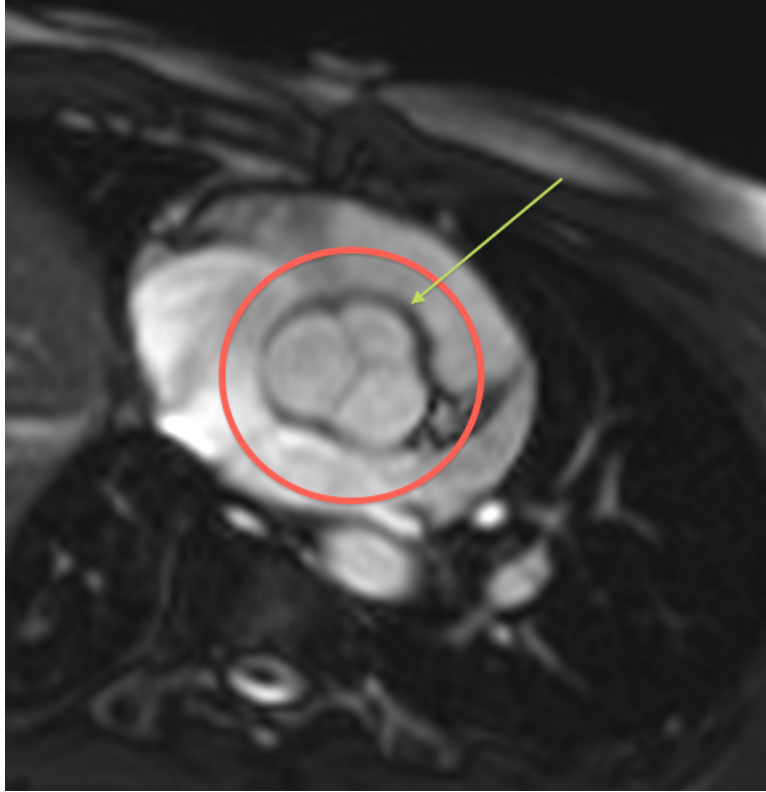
An MRI image of the selected patient in which it is possible to see the aortic valve (in the red circle). In the image, it is still possible to individuate the three leaflets, but the one pointed to by the green arrow is clearly smaller than the other two, suggesting a BAV case.
